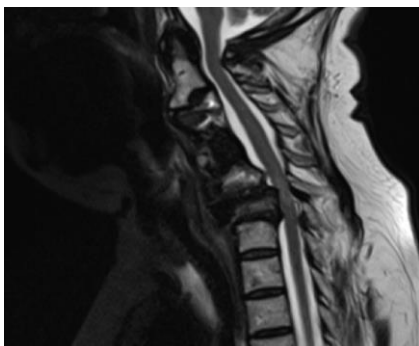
MRI revealed kyphosis with severe spinal cord compression
